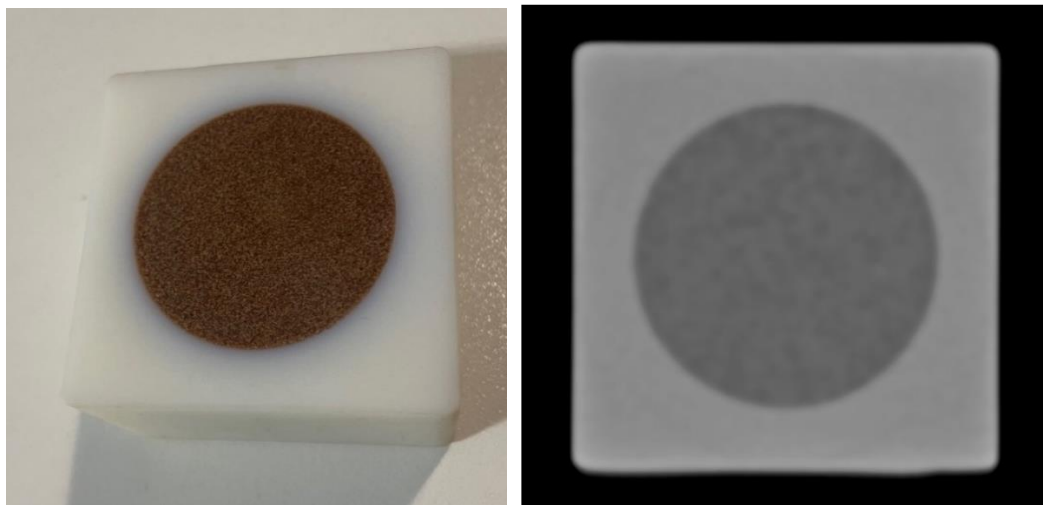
Left: Photograph of hybrid sample; Right: corresponding CT scan. Hounsfield unit testing demonstrated contrast between the Vero White and water equivalent material of approximately 130 HU with no bleeding of one material in to the other
